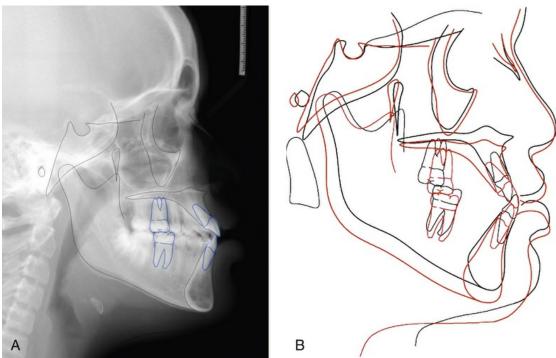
A, Posttreatment lateral cephalogram. B, Tracing and radiographic superimposition *Black* (pretreatment); *red* (posttreatment).
